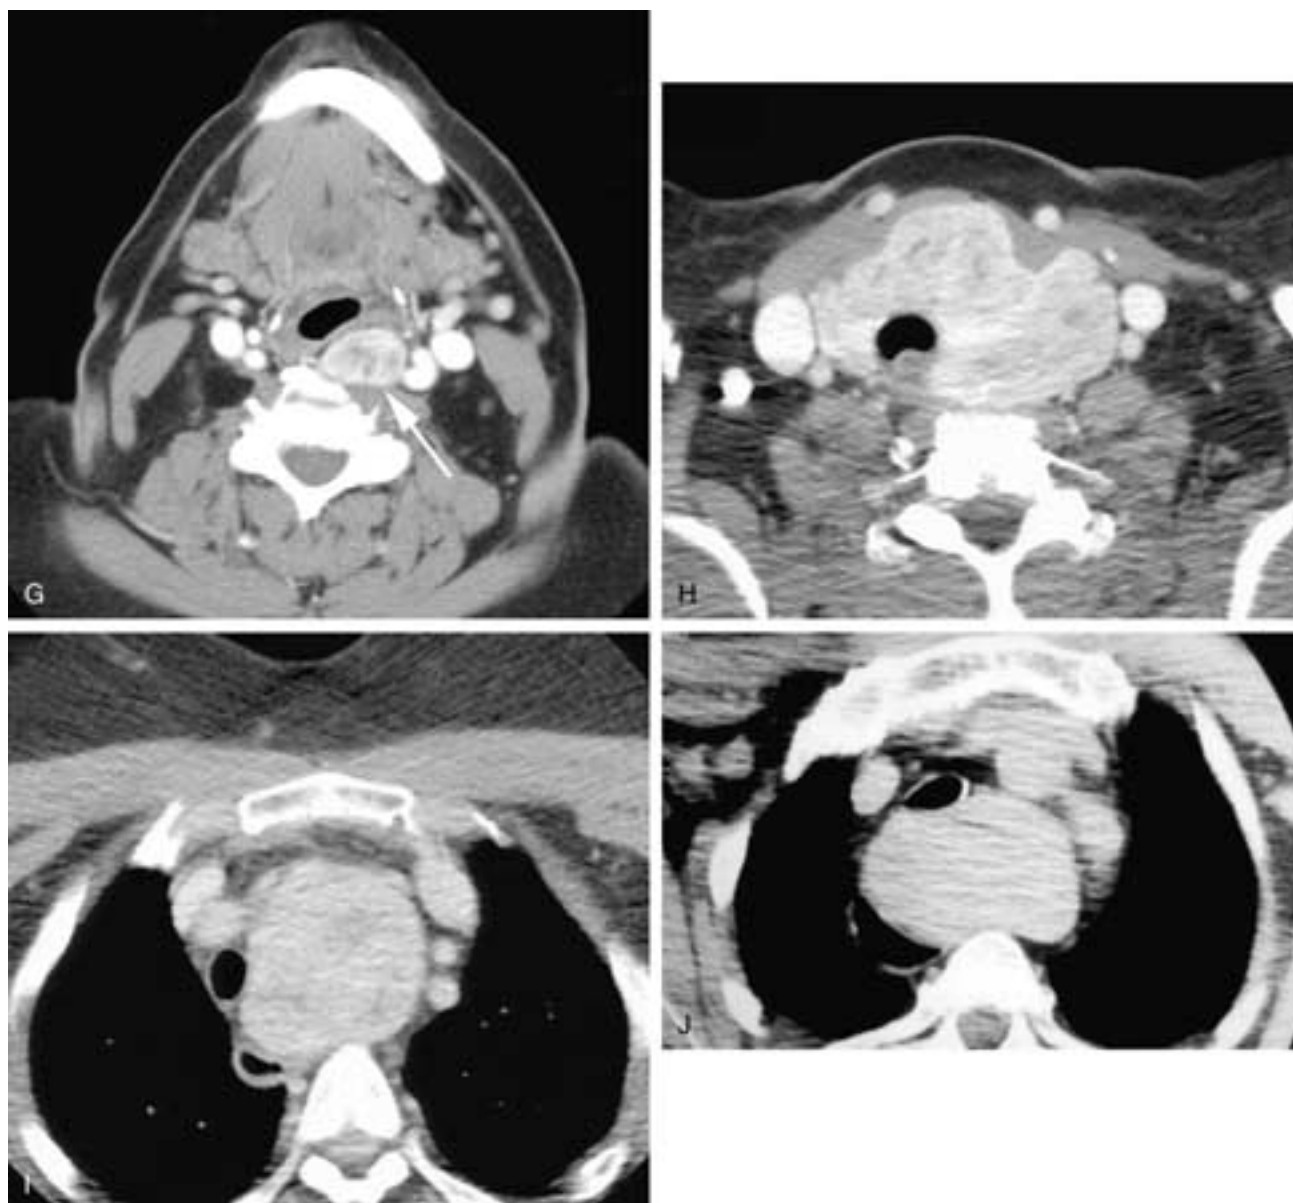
Continued.* Axial contrast-enhanced CT scans at the level of the middle to upper oropharynx (G) and the thyroid bed (H) of another patient with a goiter. The larger left thyroid lobe (*arrow*) extends up via the retropharyngeal space. Axial contrast-enhanced CT scan (I) shows a thyroid goiter extending down into the pretracheal space portion of the visceral space behind the sternum. Axial CT scan (J) shows a thyroid goiter extending down into the retrovisceral portion of the visceral space behind the trachea.
